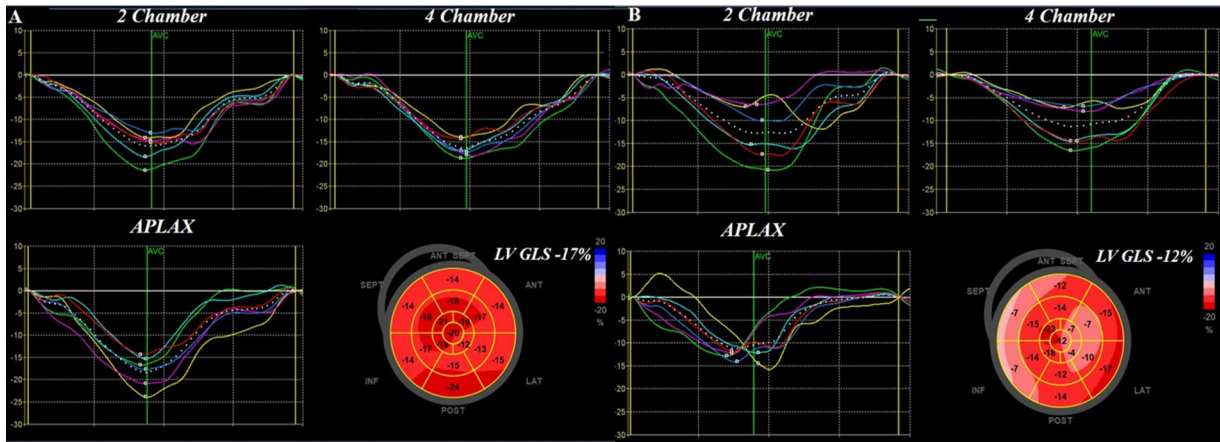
Example of assessment of LV GLS by speckle tracking strain echocardiography in a woman with SSs (panel A) versus a man with SSs (panel B). Color-coded Bull's eye plots and the curves for longitudinal strain (panel A, LV GLS=-17%, panel B, LV GLS=-12%) are displayed; the strain curves are showed per segment and averaged among the segments (dotted line for the three-chamber, four-chamber and two-chamber apical views). LV GLS, left ventricular global longitudinal strain; SSs, systemic sclerosis.
